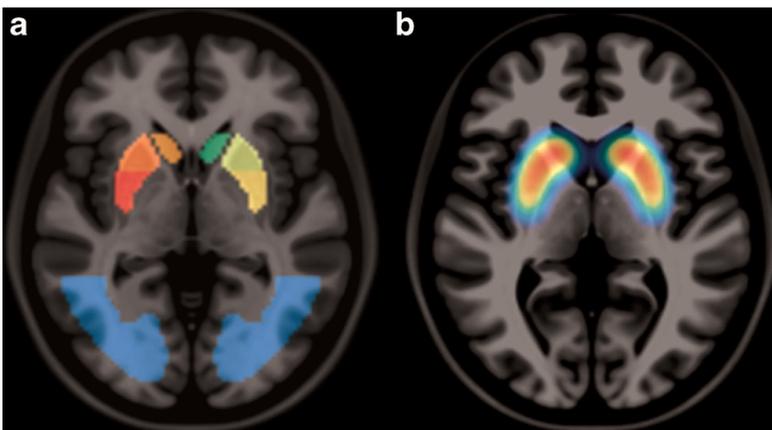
Implementation of new 3D VOIs for the semiquantitative analysis. (a) Newly implemented VOIs (caudate nucleus, anterior and posterior putamen, and the occipital cortex) adapted from the Automated Anatomical Labeling (AAL) atlas and coregistered to the MNI MRI template. (b) New healthy control [¹²³I]FP-CIT SPECT template implemented in EARL-BRASS generated from 103 corrected scans obtained in healthy controls, which were normalized and coregistered to the MNI MRI template. Figure from [1], Copyright © Springer-Verlag Berlin Heidelberg 2016.
